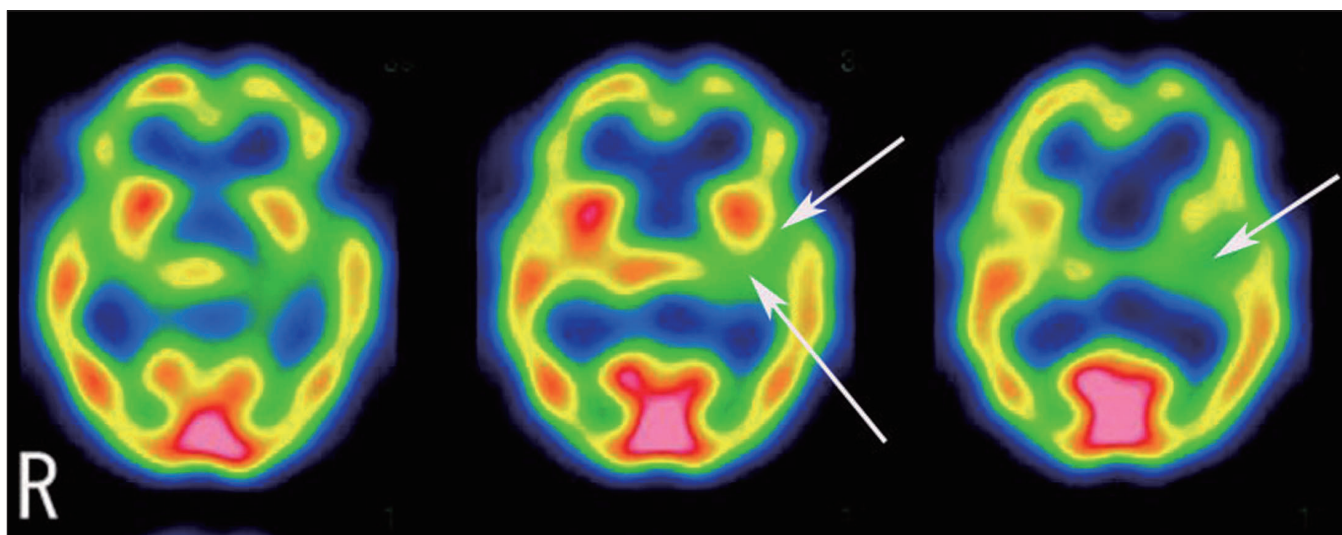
In September, single photon emission computed tomography (SPECT) images using technetium-99m ethyl cysteinate dimer (ECD) show reduced perfusion in the parieto-temporal regions, especially the left temporal area.
